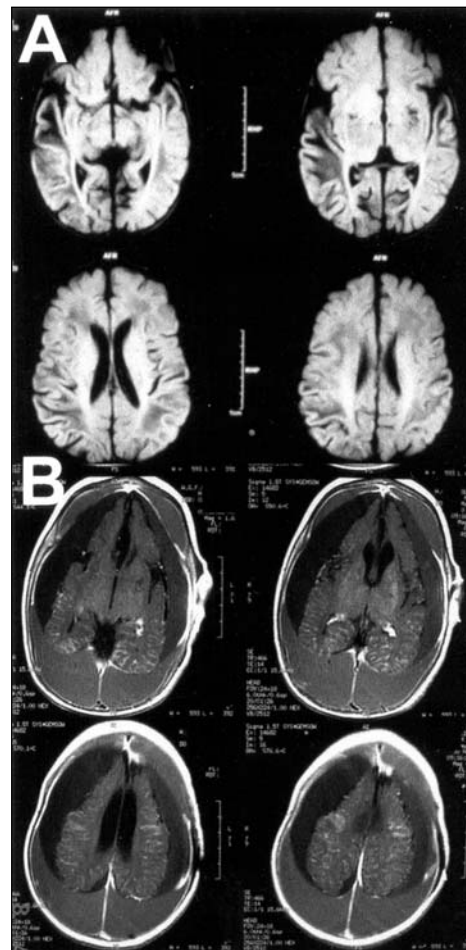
MRI, with axial slices revealed that: (A) at two months of age showed hypointensities of white matter, with higher signal intensity over right temporal lobe; and (B) at seven months of age T1-weighted slices showed hematomas ranging from isointense to moderate hypointense signal over the subdural and epidural regions, with marked atrophy of the whole brain.
